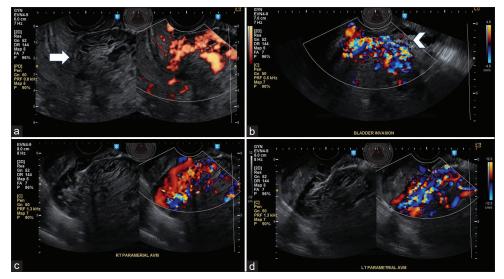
Transvaginal ultrasound with Doppler study: (a) The spongy vascular mass at the anterior midcorpus (arrow), (b) Extension of the turbulent flow to the urinary bladder base (arrowhead), (c and d) demonstrates extension of the turbulent flow up to the bilateral parametria
